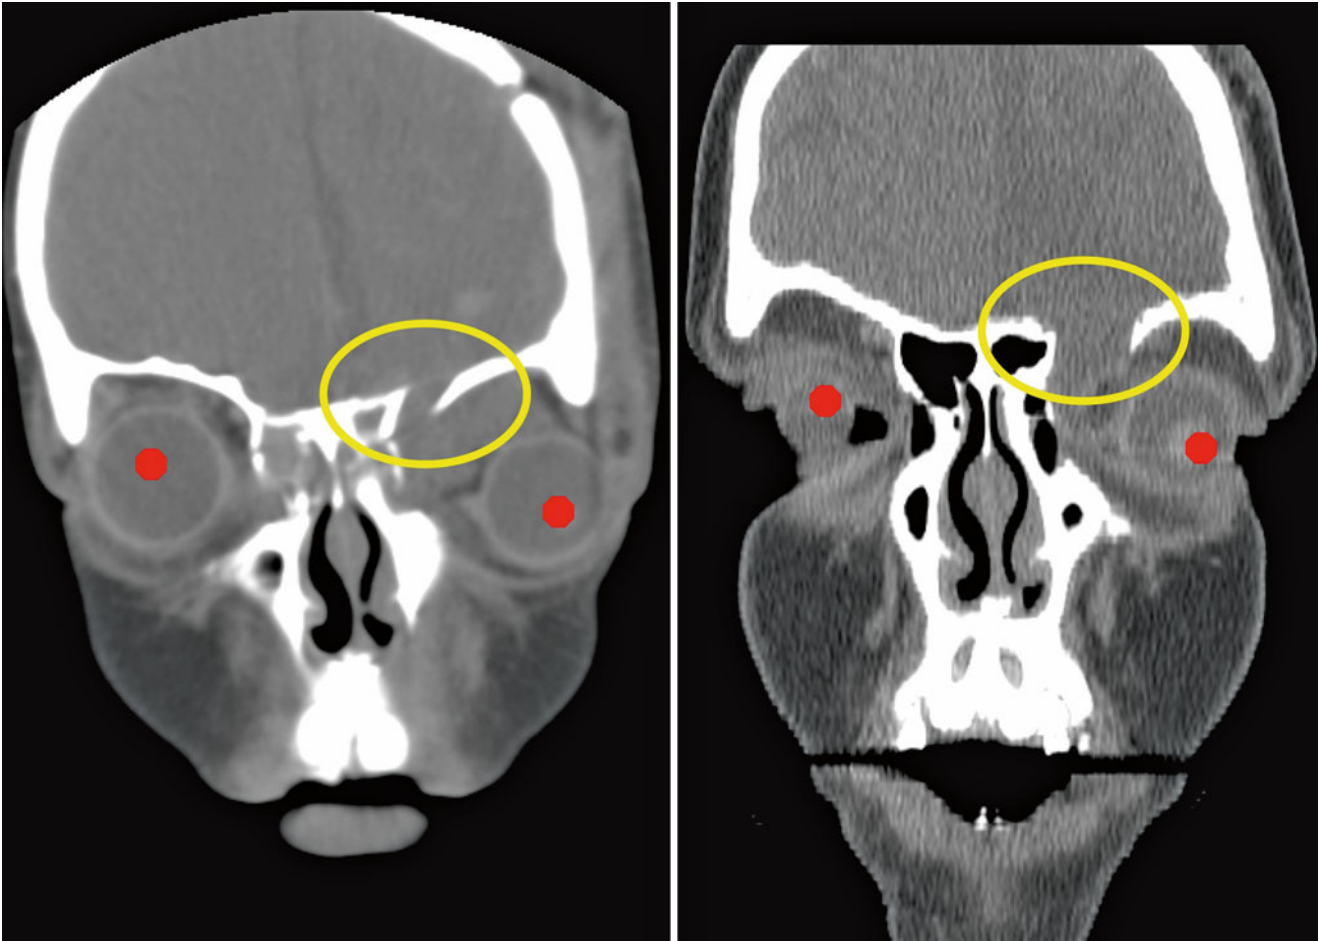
Coronal CT corresponding to clinical photo in Fig. 23.9. The yellow circle indicates the growing skull fracture
